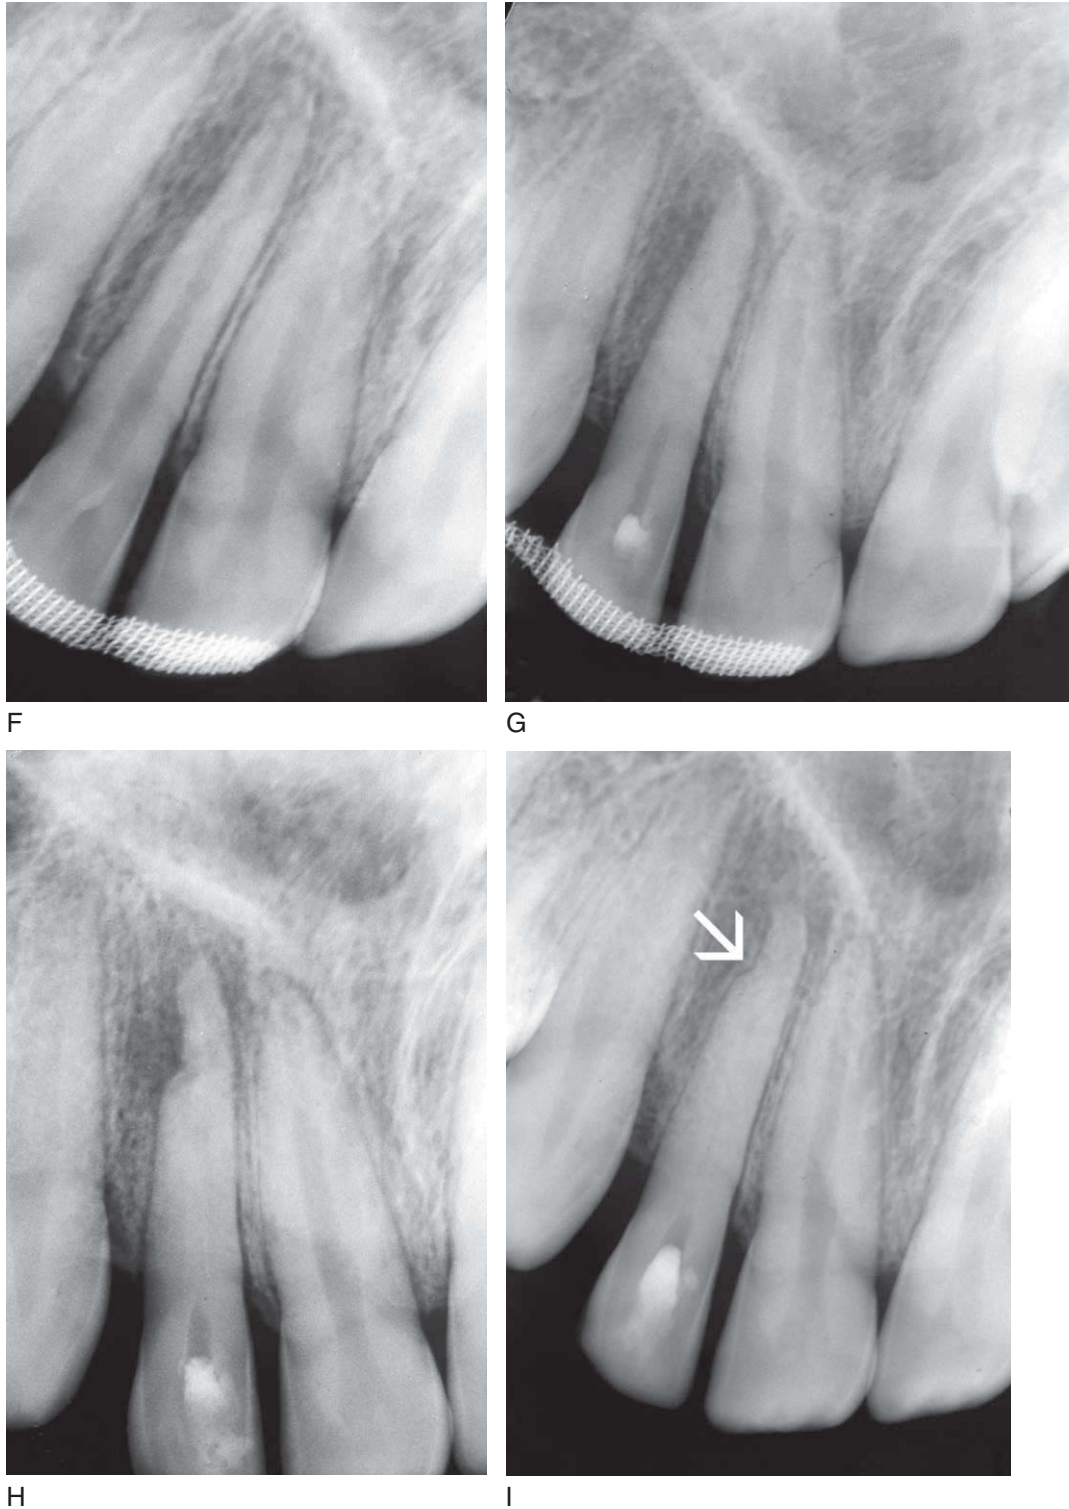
cont'd F, Radiograph with tooth positioned in place. G, Radiograph with calcium hydroxide placed in canal 10 days posttrauma. H, Six months posttrauma, inflammatory root resorption and an associated radiolucency visible apically/distally. I, Twelve months posttrauma, resolution of the inflammatory root resorption and of the radiolucency are visible and the PDL has reestablished itself (*arrow*).
